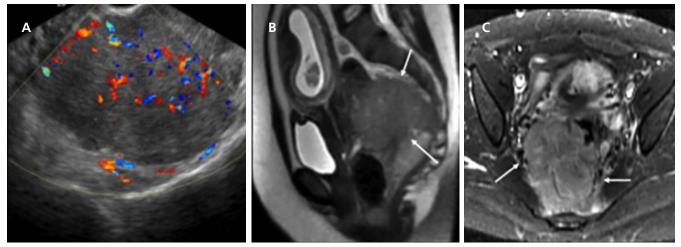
Rectal mass in pregnancy. A 40-year-old woman presented in her 11th week of pregnancy with bloody diarrhea. US (A) showed a vascular rectosigmoid mass. Sagittal (B) and axial (C) MR images showed a soft-tissue mass arising from the rectosigmoid colon (white arrows). Biopsy revealed squamous cell carcinoma.
